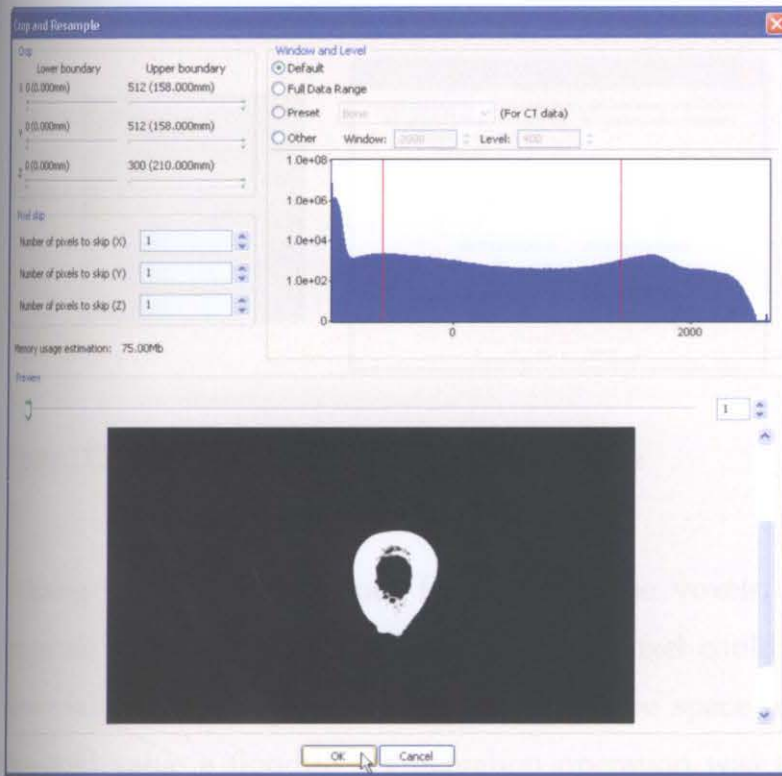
Pre-set window width and level for visualisation of CT scan slices
